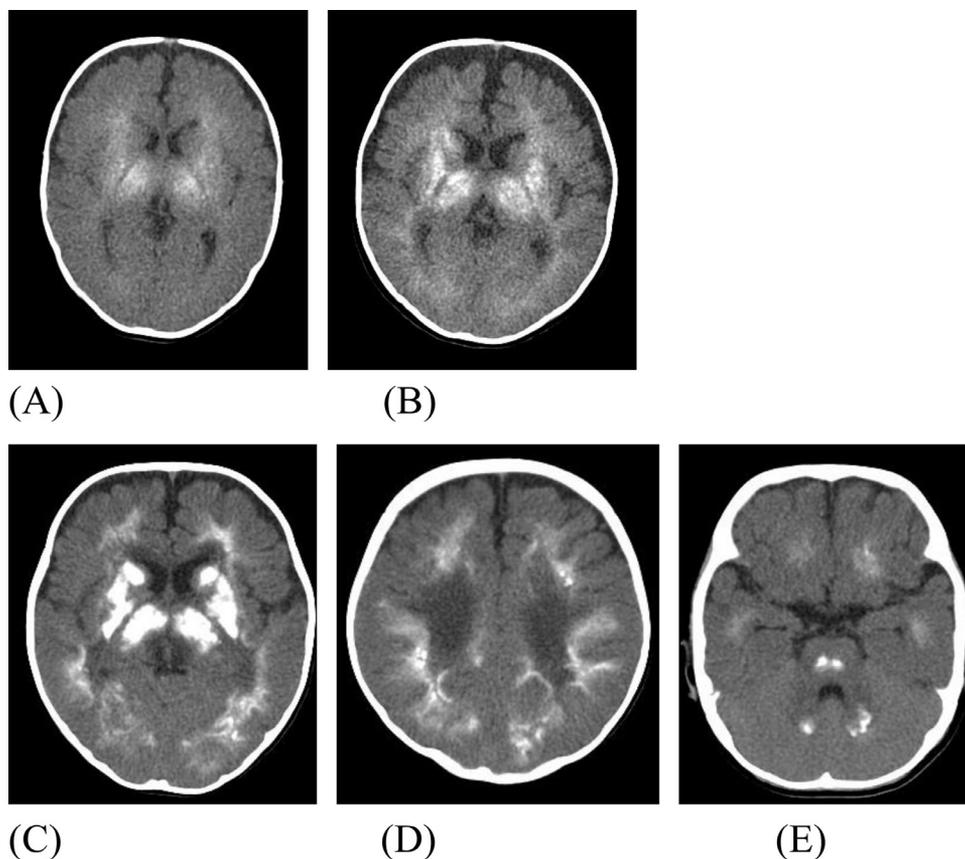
Axial computed tomography images showed intracranial calcifications in the basal ganglia and thalamus at 3 months (A) and 6 months (B). Calcifications developed in the cerebral white matter, pons, and cerebellum at 1 year and 4 months (C-E).
